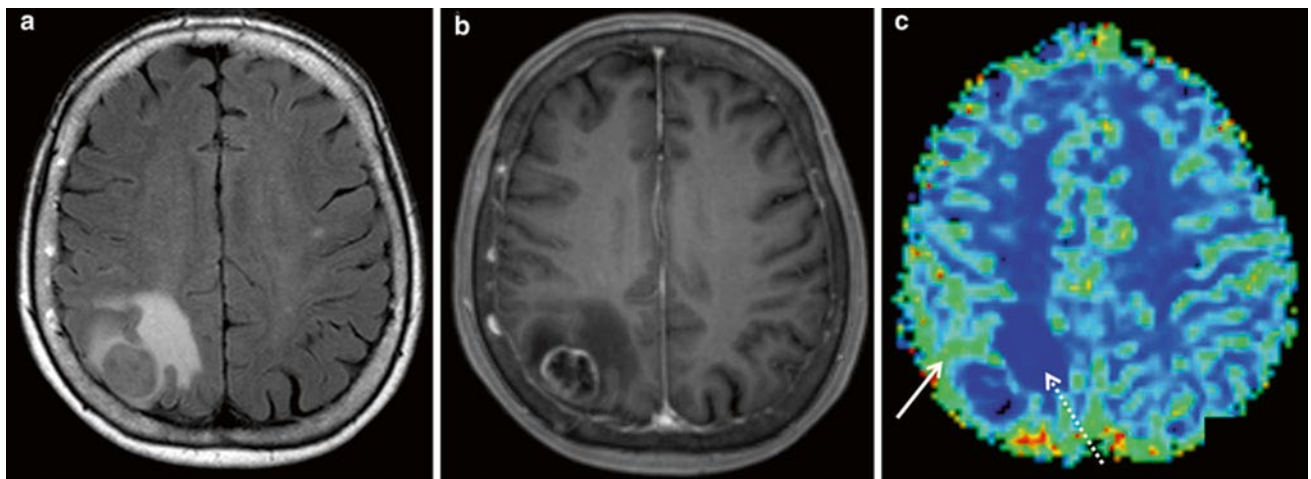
Metastasis of a bronchial carcinoma (NSCLC): (a) axial FLAIR, (b) post-Gd T1w, and (c) DSC rCBV map of a selected slice. Elevated rCBV values are seen in the rostral part of the contrast-enhancing lesion (*arrow*) but not in the perifocal edema (*dotted arrow*)
